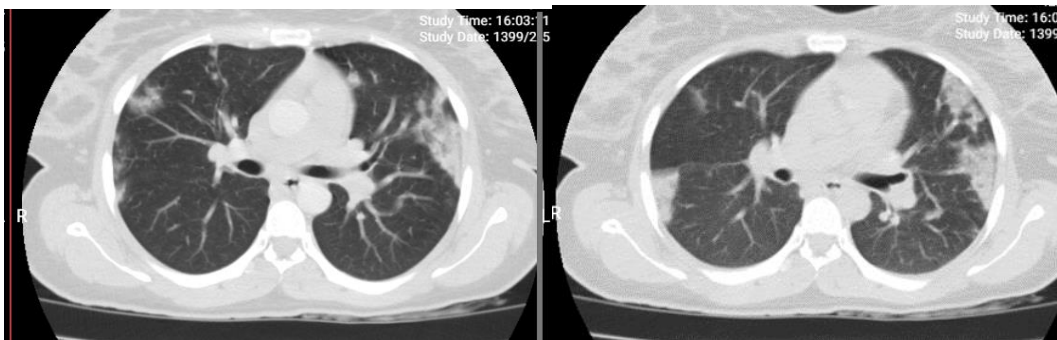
Chest HRCT of the patient during hospitalization: bilateral peripheral grand glass opacity
